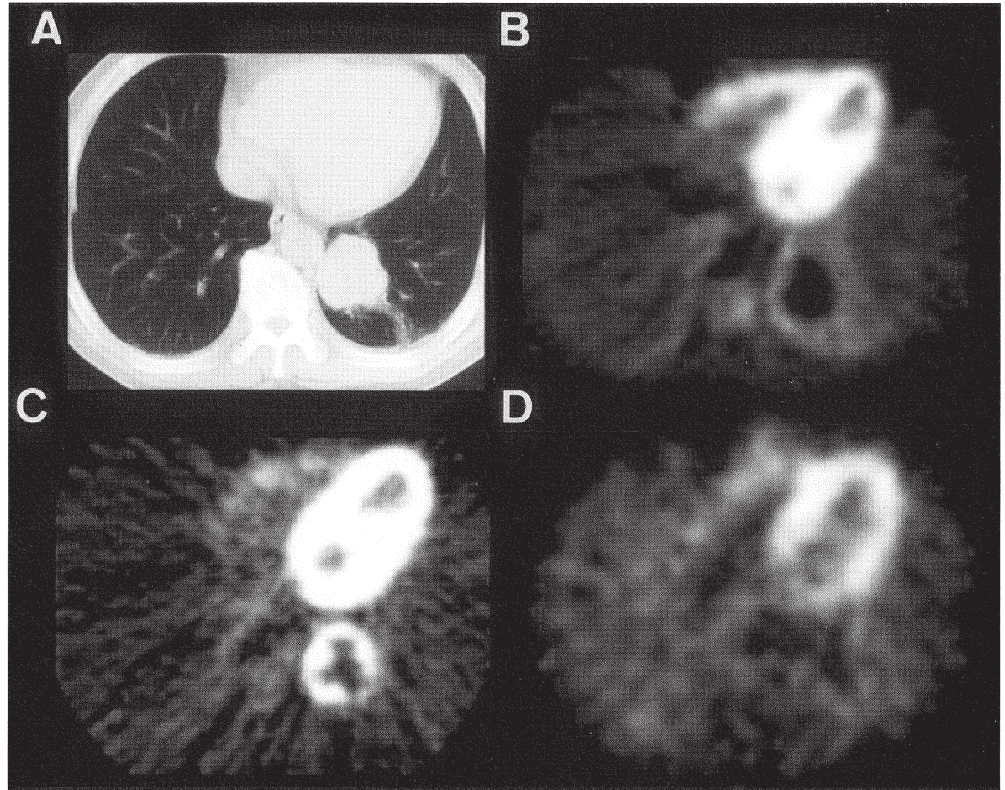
Patient 1: bronchiolo-alveolar carcinoma, 2.6 cm in maximal diameter, pathological stage 1A (T1N0M0), non-aggressive lung cancer. A CT shows a nodule in the left lung. B AC PET reveals good visualisation of the nodule (SUV, 1.82; T/N, 2.90). C FDG PET does not reveal any lesions (SUV, 0.93; T/N, 1.00). D MIBI SPET shows weak accumulation (T/N, 1.85) in the lung cancer. The patient suffered no recurrence, and was alive 33 months after surgery
